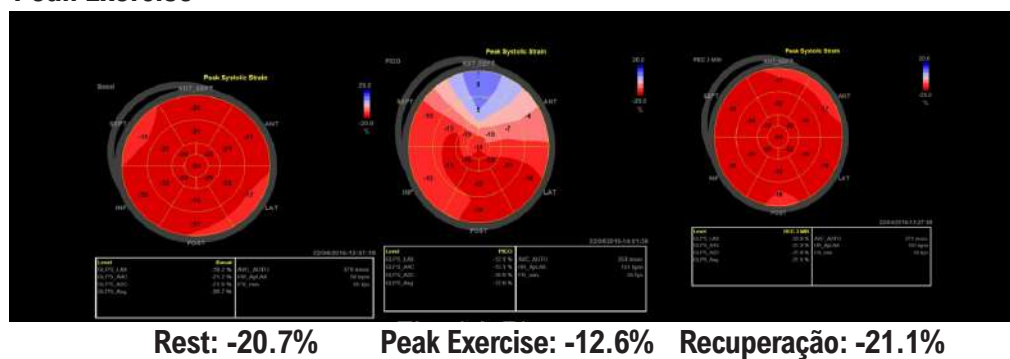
A 65-year-old patient. Stress echocardiography positive for ischemia in the apical, anterior septal, anterior, and inferior segments, with a global longitudinal strain of -20.7% at baseline, -12.6% at peak stress, and -21.1% in the recovery period. Coronary angiography: Severe obstruction of the right coronary and left anterior descending arteries. This case exemplifies that resting strain does not predict the outcome of stress echocardiography and has no ischemic memory.
